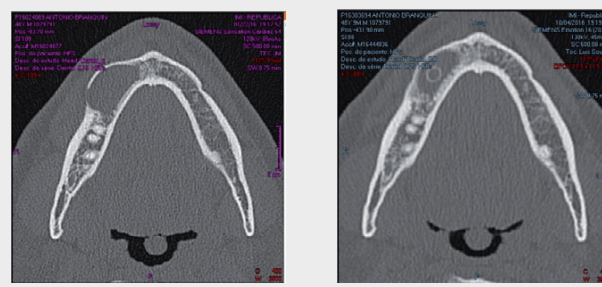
Initial CT Scan (lesion with 27mm mesio-distal diameter, 15mm vestibular-lingual and 20mm craniocaudal) and CT Scan 6 months after drain placing (24mm MD and 11mm VL)
